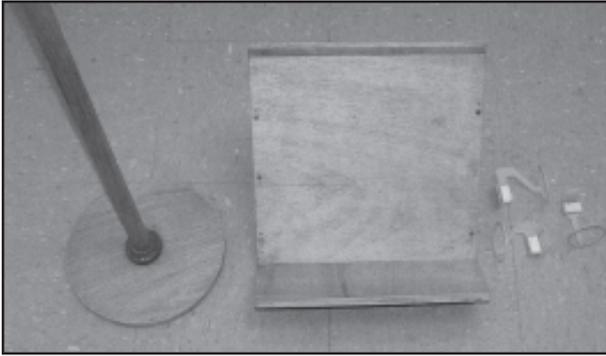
Supports used for the skull: wooden pole, inclined plane and periapical film support
